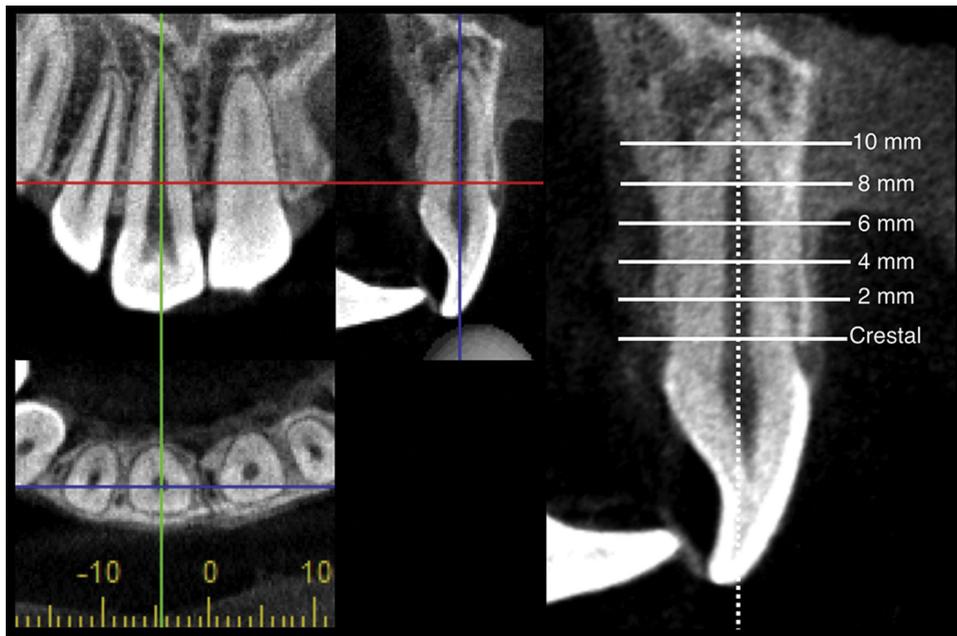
Tooth orientation, vertical references. Each CBCT image shows the tooth long axis and the sagittal plane running transversely through the midpoint of the long axis. The vertical levels of maxillary teeth were measured from the crestal bone level to 2 mm, 4 mm, 6 mm, 8 mm, and 10 mm apical to the crestal bone level.
